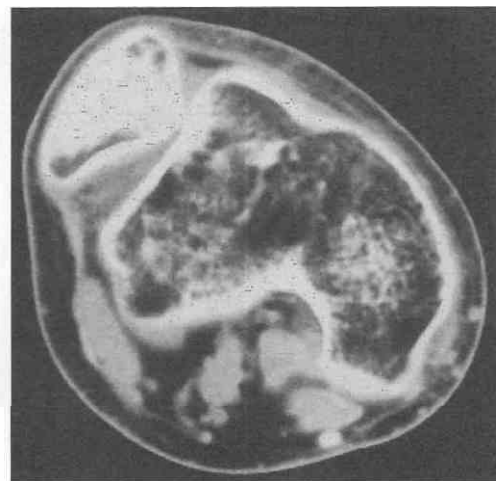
Patellofemoral dislocation. Axial CT scan of the right knee in this patient with cerebral palsy shows chronic patellofemoral dislocation. The femoral trochlear sulcus is hypoplastic.
